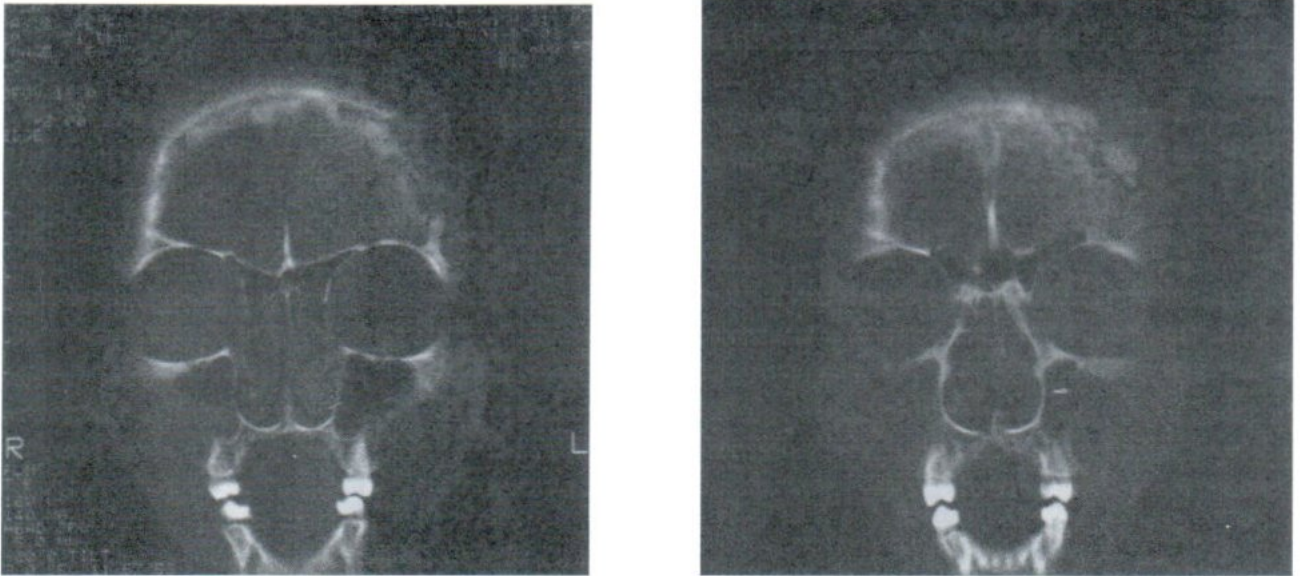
Case 1. Bone window of the CT scan , mild expansion of the medulla of the frontal bone was observed.
